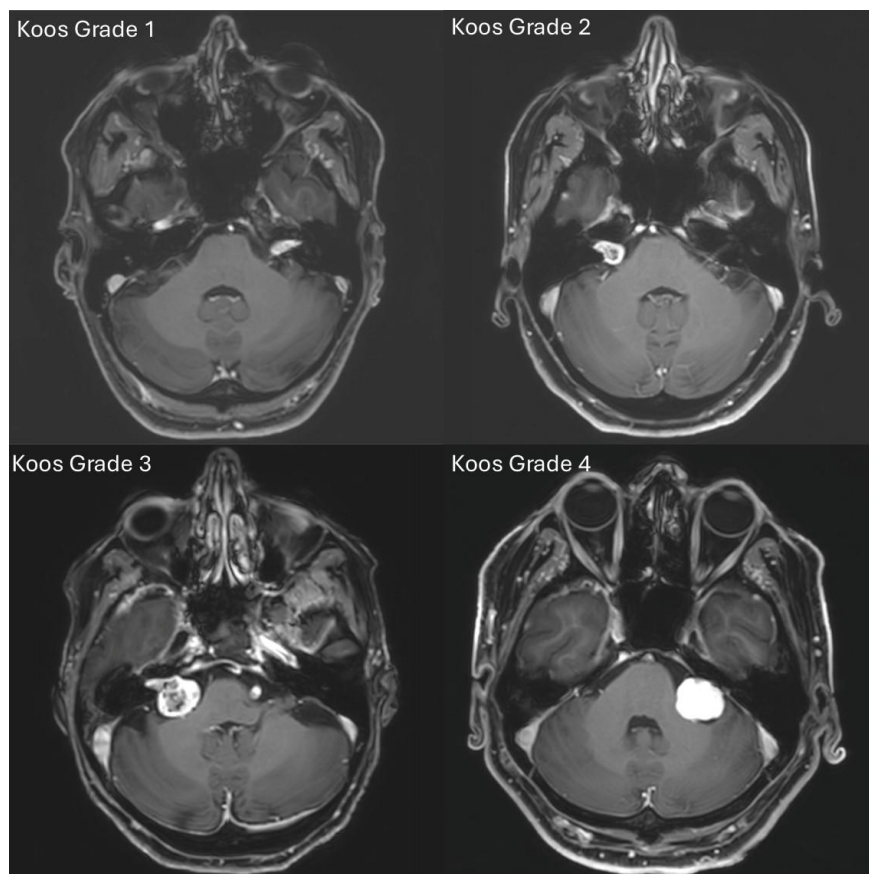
Contrast enhanced T1-weighted MRI depicting the classification of VS as described by Koos²⁵
